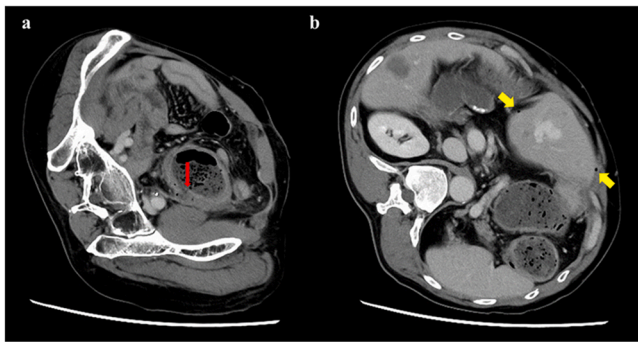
Abdominal computed tomography scan showing a low-density area with thinning of the sigmoid colon wall (red arrow) and extraluminal air (yellow arrow).
